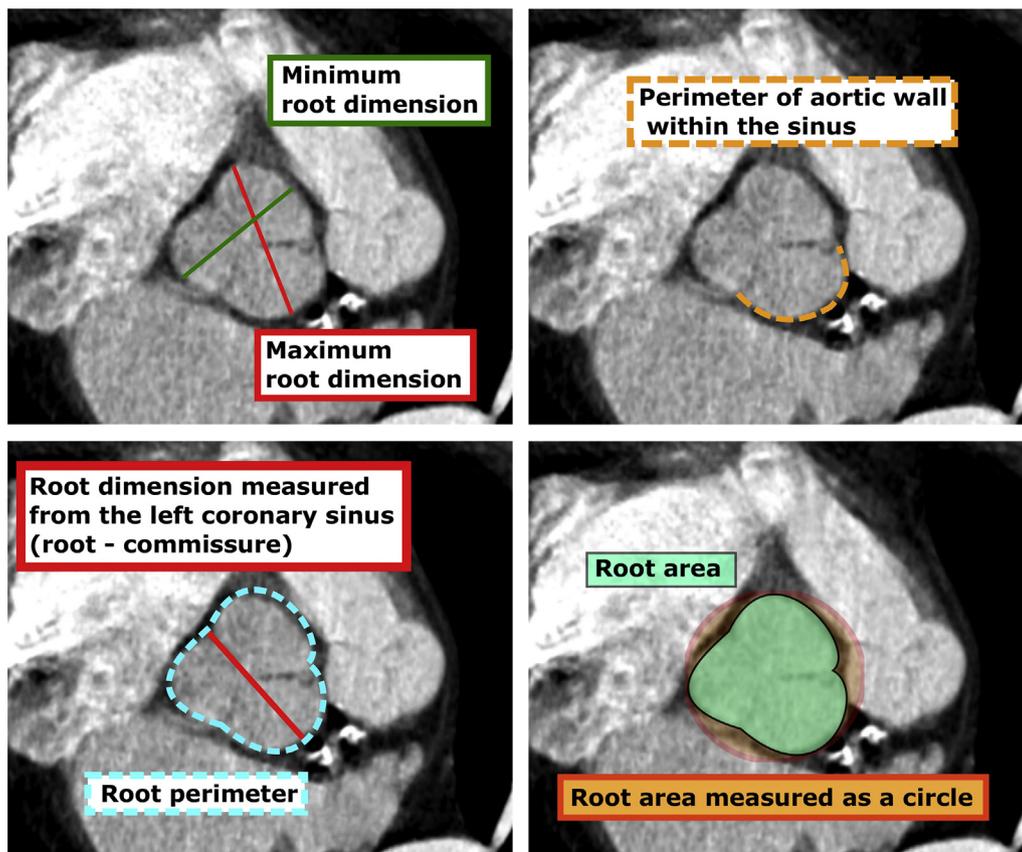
Measurements of the aortic root performed on a plane perpendicular to the long axis of the vessel using the CT angiography with 3D multiplanar reconstruction.
